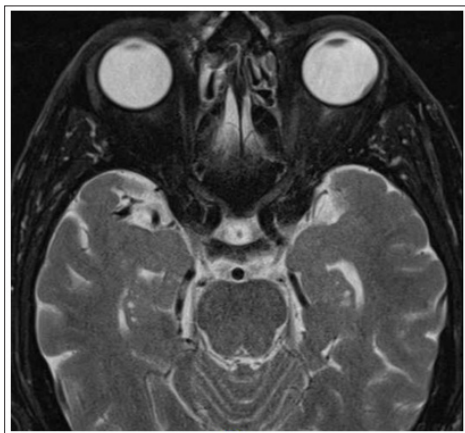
T2 weighted MRI orbits demonstrating an ill-defined non-enhancing curvilinear lesion along the lateral margin of the left ocular globe
